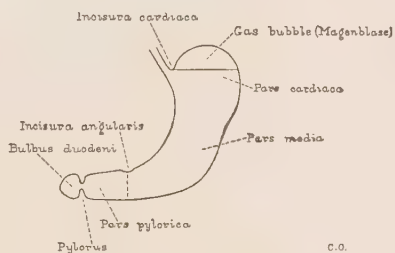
Steer-horn stomach. A transverse type of stomach infrequently shown by roentgenogram (Carman).
